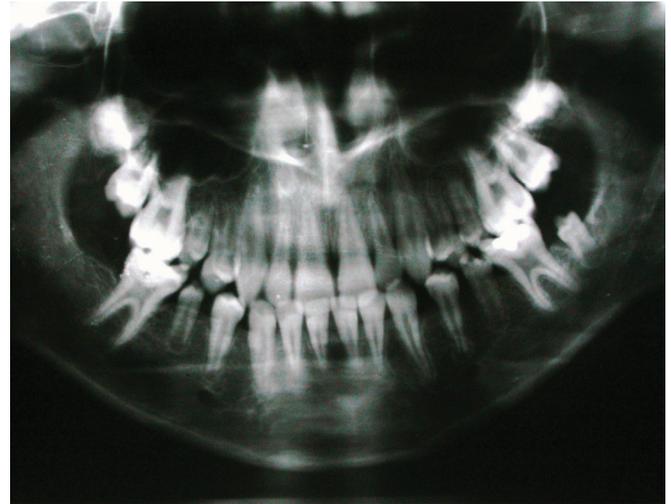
The panoramic radiograph revealed the absence of a tooth bud for 47, microdontia of 37 and 45, and secondary caries of 46.
